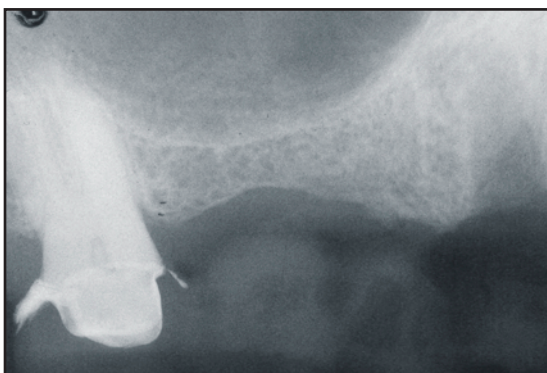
Case 4. Patient presented with a need for implant placement at site #3 through #5 as depicted by the radiograph.
